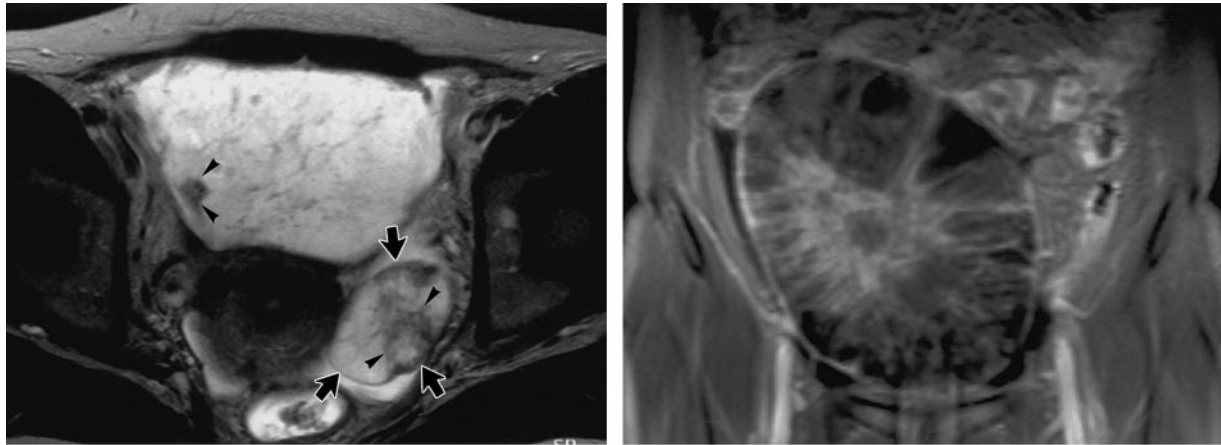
Bilateral Krukenberg tumors from gastric carcinoma in a 38-year-old woman. (a) Axial turbo spin-echo T2-weighted MR image (5,200/132) shows bilateral cystic masses with hypointense solid portions (arrowheads). The left-sided mass (arrows) is much smaller than the right-sided mass. (b) Gadolinium-enhanced fat-suppressed FLASH T1-weighted MR image (147/4.8) shows the mass with marked enhancement of the septa and solid components.
